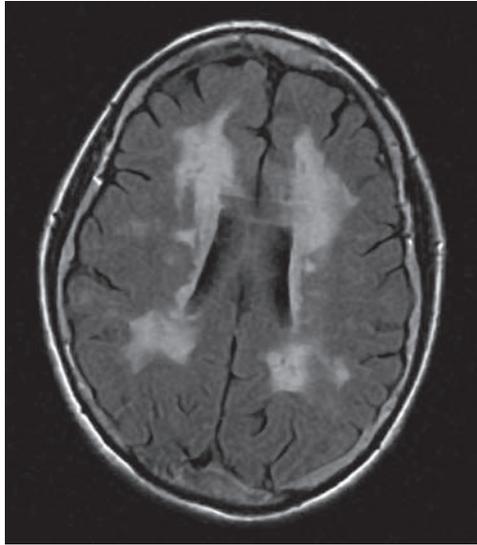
Axial flair MRI showing subcortical white matter abnormality in CADASIL.
